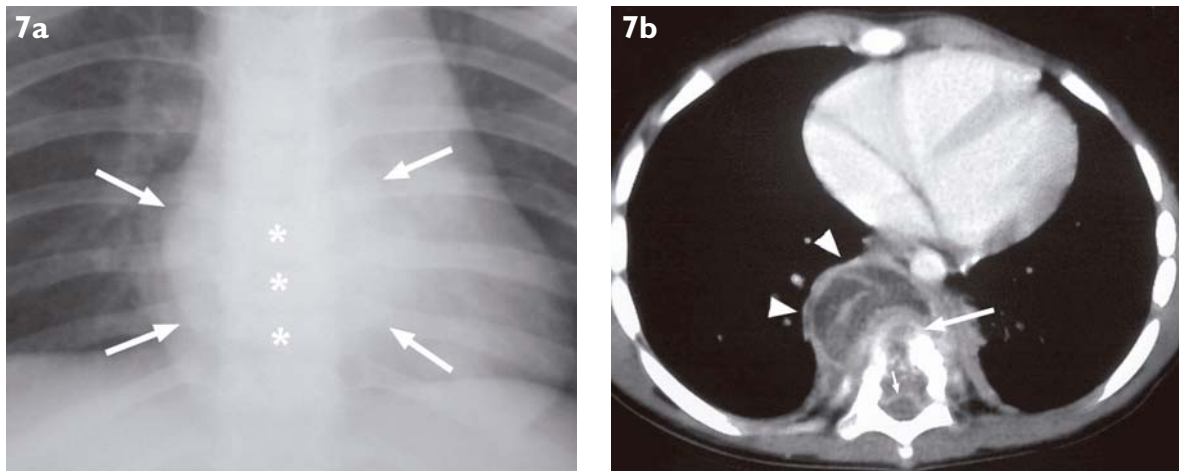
2-year-old child with TB spondylitis. a) AP chest radiograph shows a large paraspinal mass (arrows) adjacent to collapsed T7-T9 (*) vertebral bodies. b) Axial CT image taken through T8 vertebral body shows vertebral body destruction (arrow). A paravertebral abscess (arrowheads) with extension into the spinal canal (small arrow) is noted.
